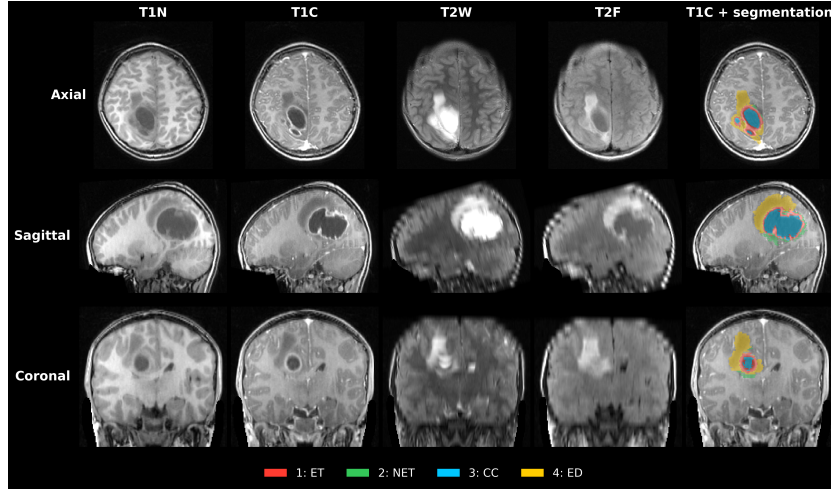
Training case showing four MRI sequences and reference standard annotations. The four tumor subregions are color-coded: enhancing tumor (ET; red), nonenhancing tumor (NET; green), cystic component (CC; blue), and peritumoral edema (ED; yellow).
